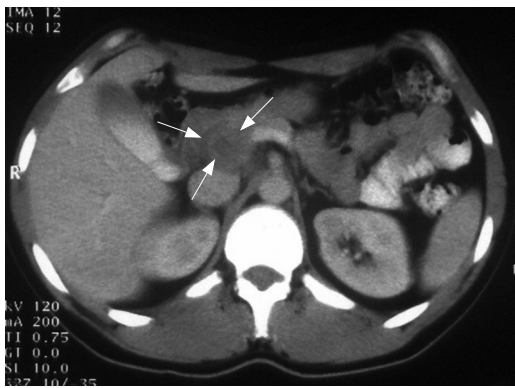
Abdominal CT-scan showing a low density mass on the posterior aspect of the head of the pancreas with contrast enhancing solid rim (arrow).
